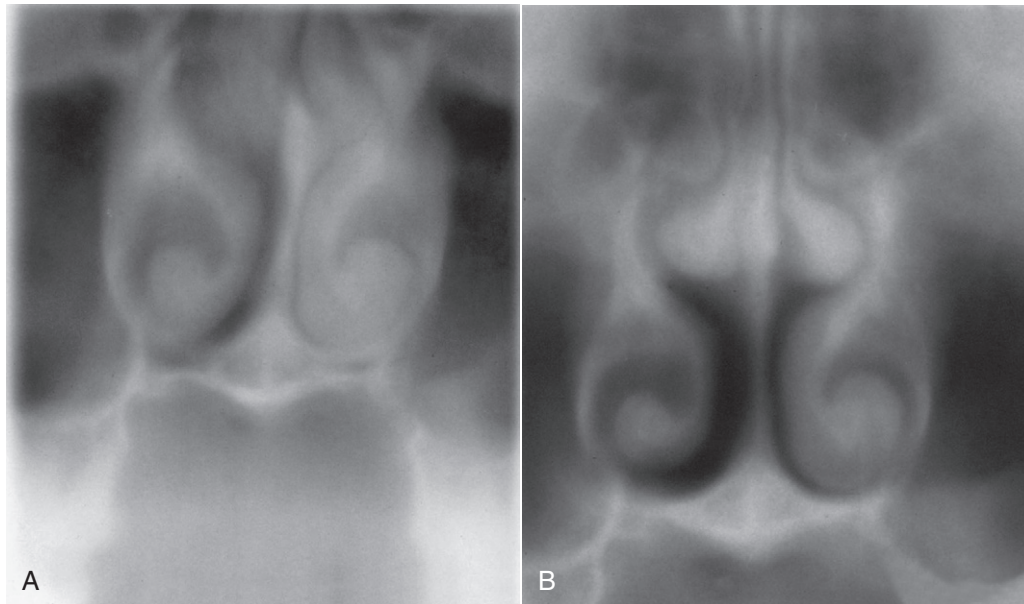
A, Pre-surgical radiograph of nasal cavity obstructed by enlarged turbinate bones. Patient has severe obstructive sleep apnea according to the apnea-hypopnea index (AHI): 76 times per hour. B, Post-surgical radiograph of nasal cavity after resection of the inferior turbinates. There was a 50% reduction in obstructive sleep apnea.
